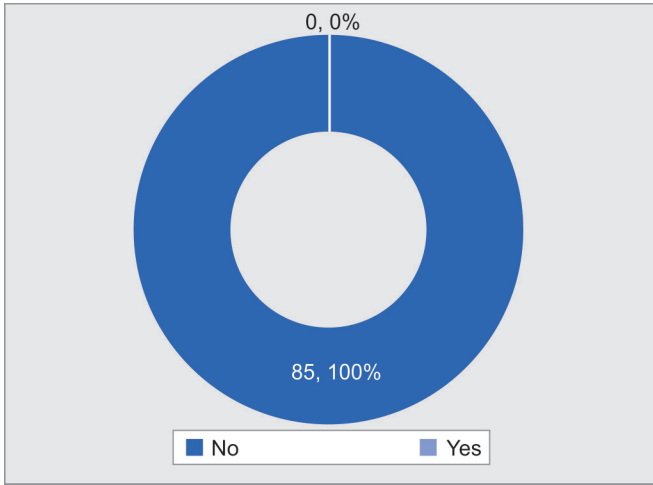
Frequency percentage of patients' regional wall motion abnormality represented by 2D echocardiography (n = 85)
